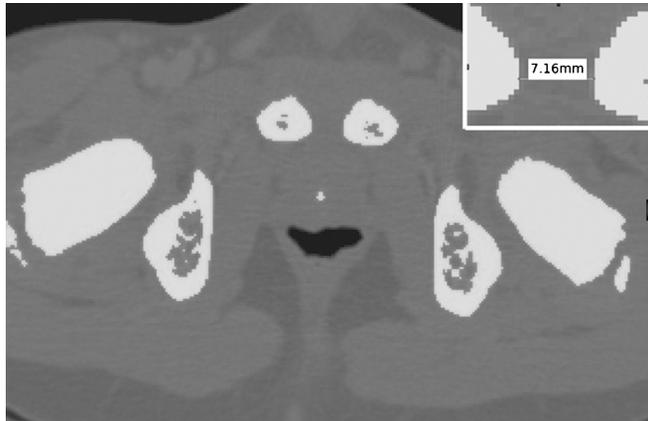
Axial CT scan image after segmentation with software. Pubic symphyseal width is measured as shown in upper right corner of image.
